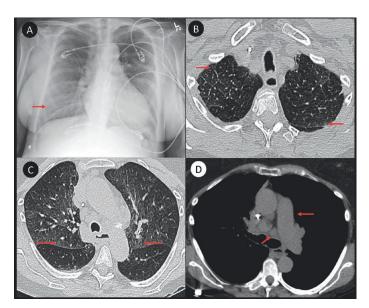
Radiologic diagnostic triad. (A) Posteroanterior chest x ray shows a prominent main pulmonary artery and Kerley B lines (arrow). (B) Axial high-resolution computed tomographic (CT) image of the upper lobes shows smoothly thickened interlobular septa (arrows) and geographic ground-glass opacities. (C) Axial high-resolution CT image shows widespread ground-glass opacities (arrows) and few septal lines. (D) Axial CT image (mediastinal window) shows dilated main pulmonary artery and enlarged mediastinal lymph nodes (arrows).
